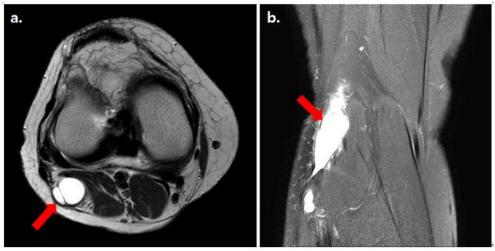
T2-weighted magnetic resonance imaging of the knee. (a) Axial image at the distal femur level, (b) coronal image of the popliteal fossa. Arrows indicate multiloculated cystic lesion in common peroneal nerve.
